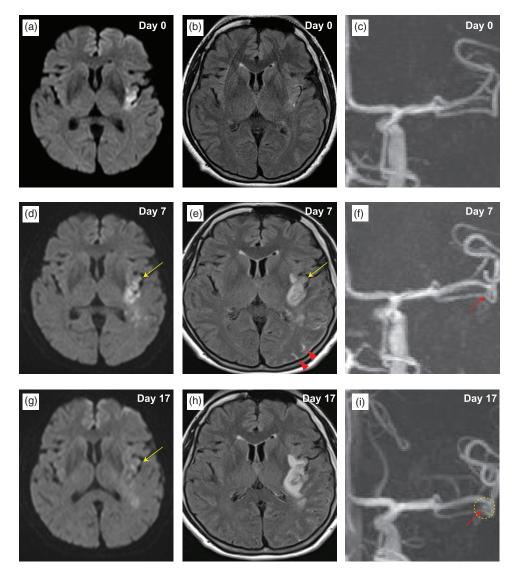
(a) Axial DW, (b) FLAIR, and (c) MRA images on day 0 of hospitalization. Arrows show an acute infarction in the left middle cerebral artery lesion, but no aneurysm. (d) Axial DW, (e) FLAIR, and (f) MRA images on day 7 of hospitalization. The lesion was expanded (yellow arrows). In addition, SAH (arrowheads) and a novel aneurysm (red arrow) appeared. (g) Axial DW, (h) FLAIR, and (i) MRA images on day 17 of hospitalization. The lesion diminished in the DW image but expanded in the FLAIR image (yellow arrows). An aneurysm developed (red arrow in yellow circle).
